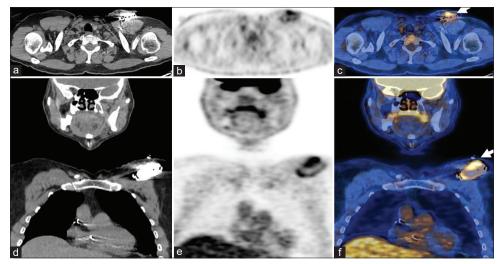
Axial and coronal noncontrast CT (a and d) ¹⁸F-FDG PET (b and e) and fused PET/CT (c and f) images showing increased FDG uptake around the pacemaker in the device pocket (white arrow). ¹⁸F-FDG PET/CT: 18F-Fluorodeoxyglucose positron emission tomography/computed tomography
